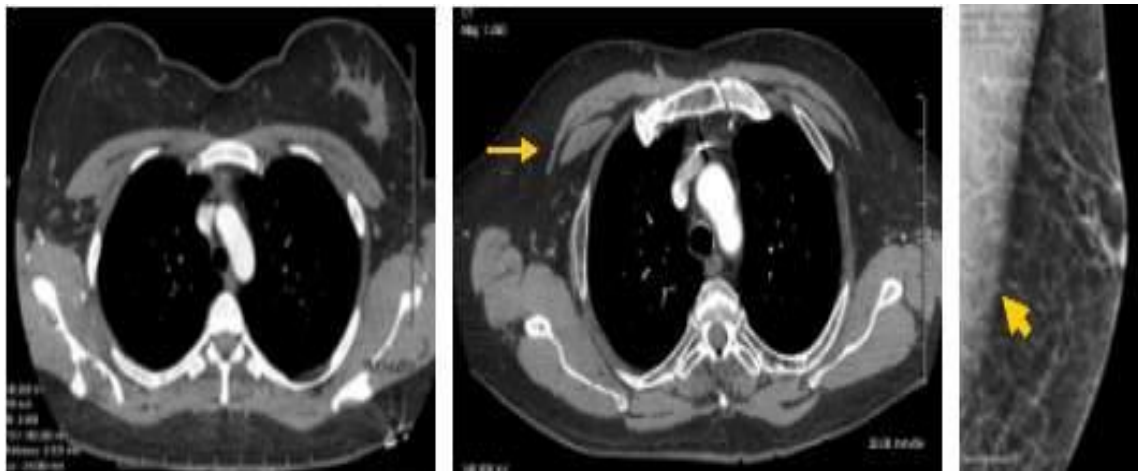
The axial CT image on the left shows the breast of an elderly woman.
